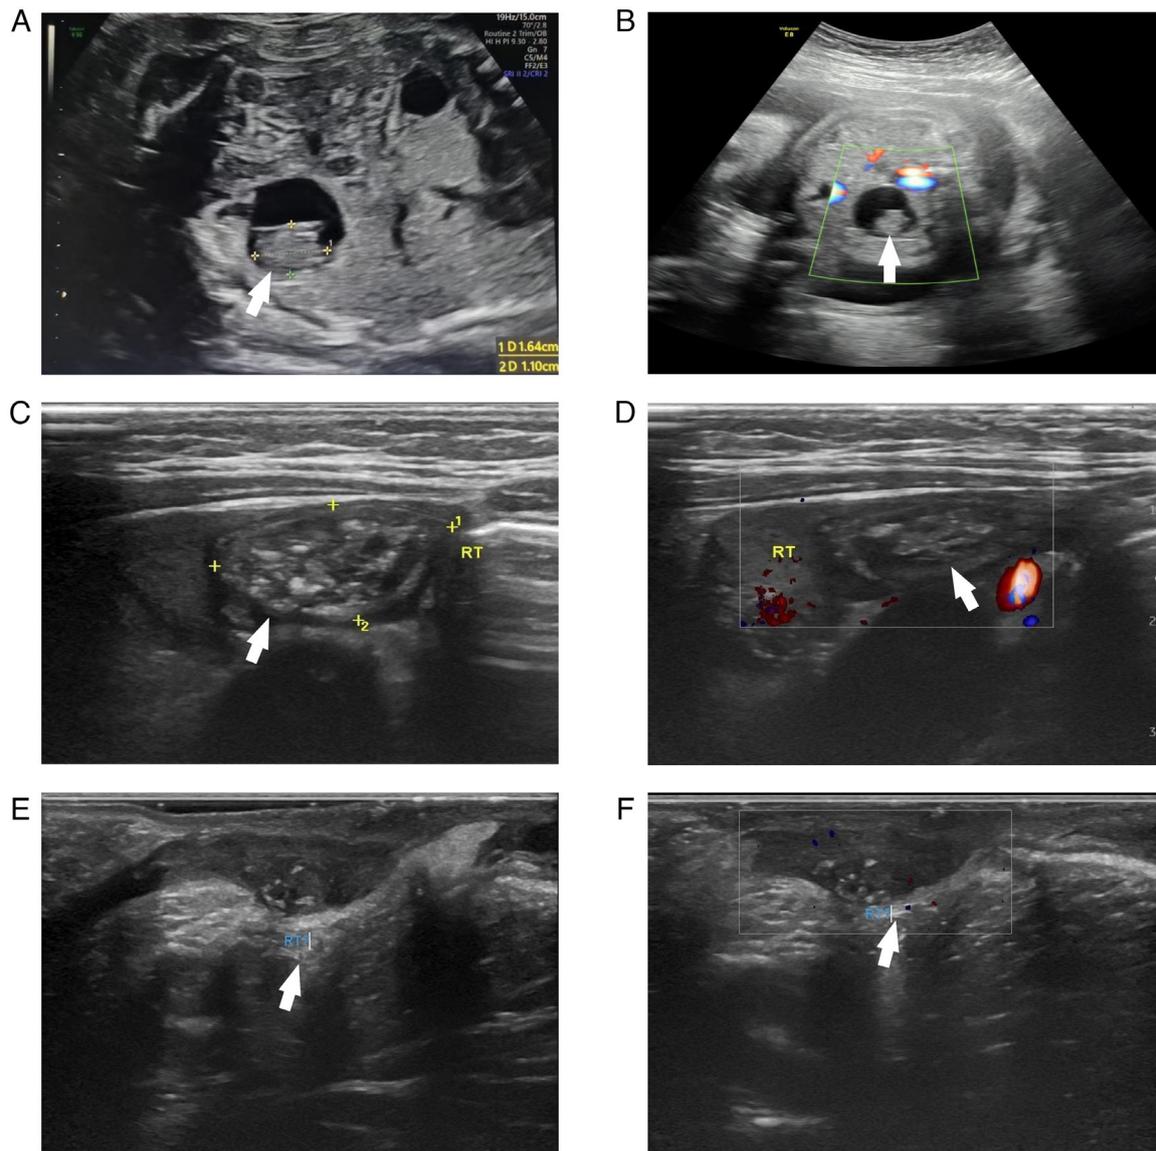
Prenatal, postnatal and postoperative sonographic findings of an intra-abdominal undescended testis with teratoma. Prenatal ultrasound at 28 weeks of gestation. (A) Transabdominal ultrasound showed a heterogeneous, well-circumscribed mass (arrow) in the right lower abdomen. (B) CDFI demonstrates scattered flow signals within the hyperechoic areas. Postnatal ultrasound at 1 month of age. (C) Ultrasound shows the persistence of the complex mass (arrow), consistent with an undescended testis associated with a teratoma. (D) CDFI reveals detectable blood flow signals within the medium-echoic areas. Follow-up ultrasound at 1 month after surgery. (E) Ultrasound shows a small testicular structure located above the scrotum. (F) CDFI shows scattered blood flow signals (arrows).
